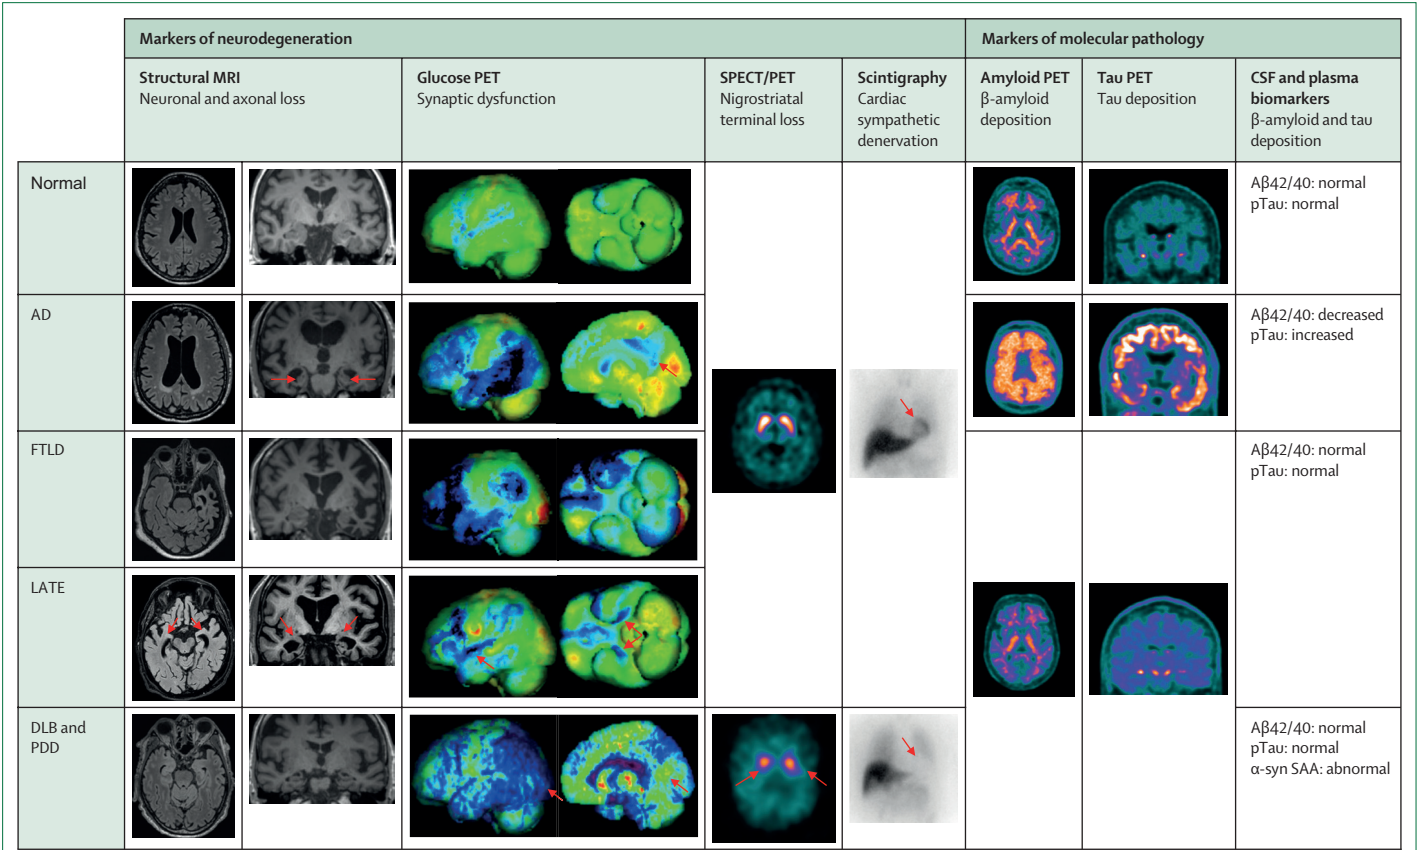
Typical biomarker profiles across pure pathology neurodegenerative cognitive disorders. Blue colour in glucose PET renderings denotes substantial hypometabolism. Orange/red/purple/white colours in nigrostriatal SPECT imaging and amyloid and tau PET denote increased tracer uptake. Images come from the archive of one of the co-authors (VG). More details in appendix (p 8). AD=Alzheimer’s disease with typical amnesic phenotype. CSF=cerebrospinal fluid. DLB=dementia with Lewy bodies. FTLD=frontotemporal lobar degeneration with behavioural phenotype. LATE=limbic-predominant age-related TDP-43 encephalopathy.¹¹⁰ PDD=Parkinson’s disease dementia. SAA=seed amplification assay. SPECT=single-photon emission computed tomography.
